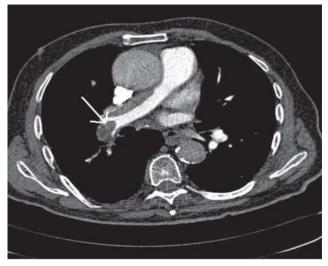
Computerised enhanced computed tomography chest showing saddle embolus at the bifurcation of the left pulmonary artery (arrow).
